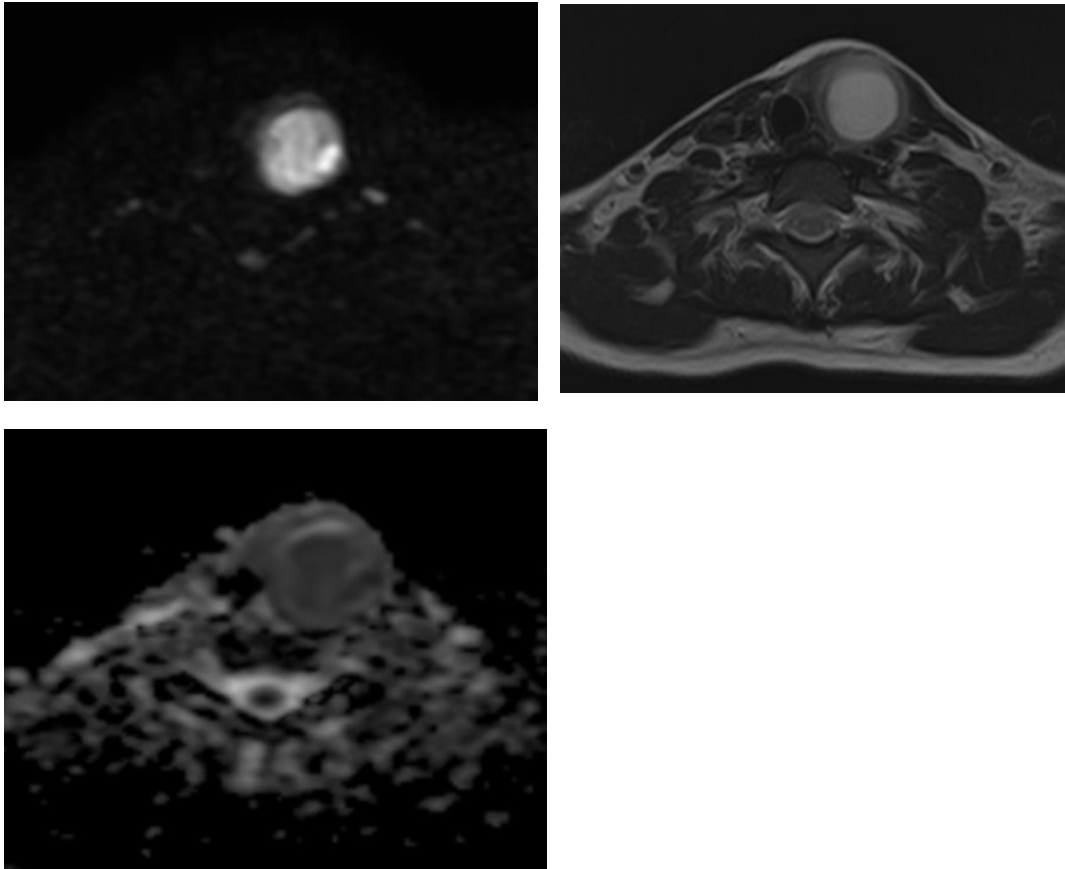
Malignant left thyroid nodule, A axial DWI and B axial T2 and axial ADC map showing a left thyroid nodule of rounded shape that elicit high T2 signal with high DWI signal denoting restricted,AT ADC map, ADV value was 0.9×10^{-3}
